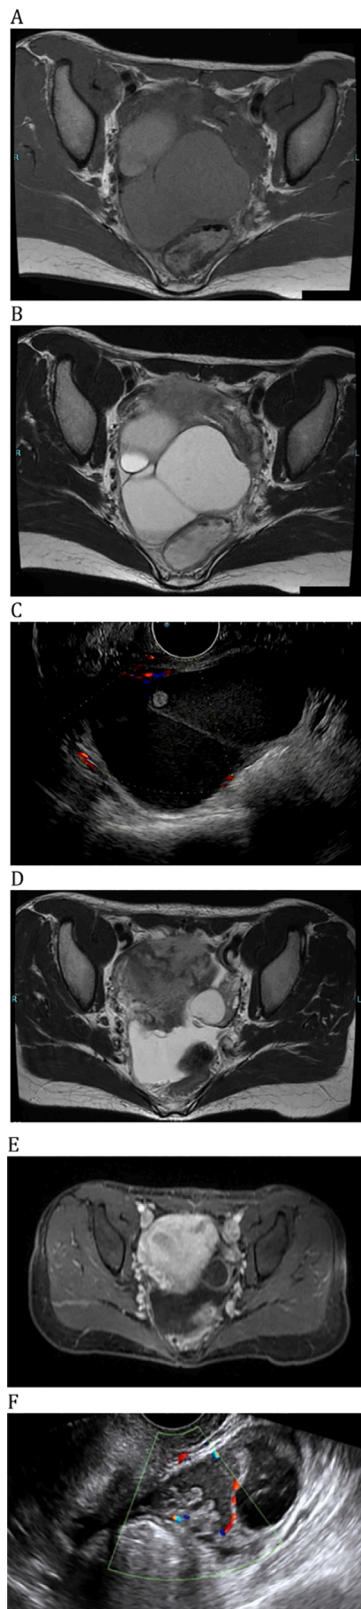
(A–C) Images taken before the initial treatment: MRI T1 (A) shows an iso-intensity multilocular 10-cm right ovarian cyst, MRI T2 (B) shows high intensity, and the transvaginal ultrasound scan (C) shows 5-mm nodules in an ovarian cyst. (D–F) Images taken during relapse: MRI T2 (D) shows an iso-intensity monolocular 3-cm right ovarian cyst. MRI T1 contrast (E) shows that the ovarian cyst wall was reinforced, although the nodule was unclear, and the transvaginal ultrasound scan (F) showed 1.5-cm nodules in an ovarian cyst.
